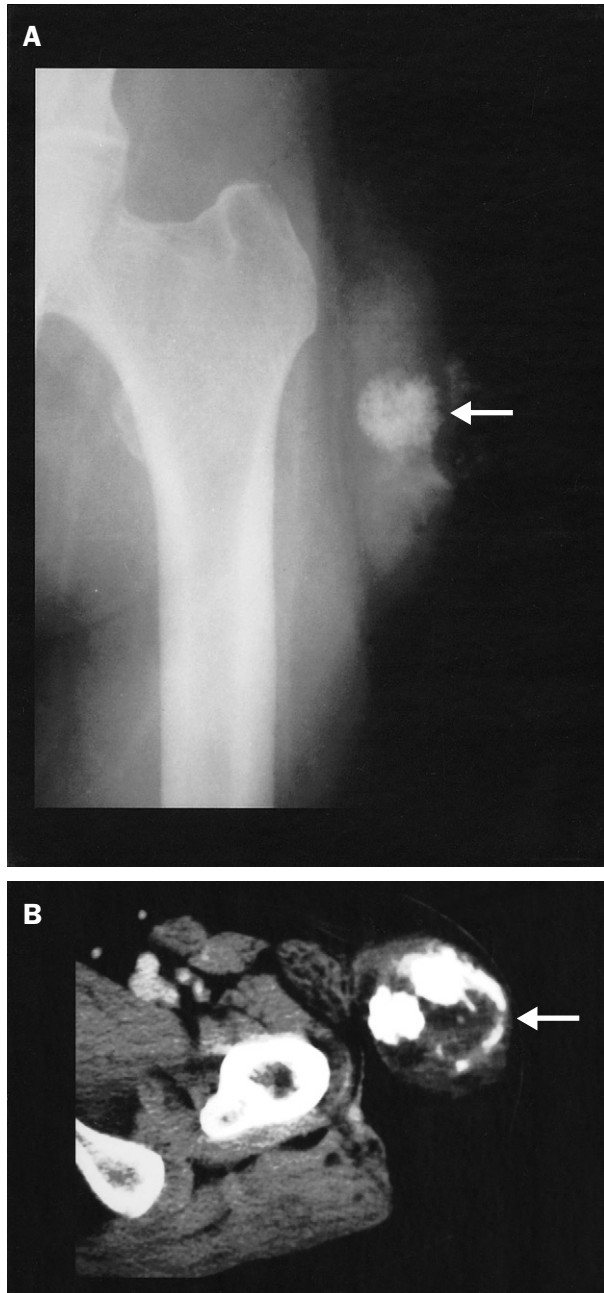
(A) X-ray shows a soft tissue mass with calcification over the left thigh (arrow). (B) Computed tomography scan shows a soft tissue mass with calcification arising from the soft tissue, without bony involvement (arrow).
